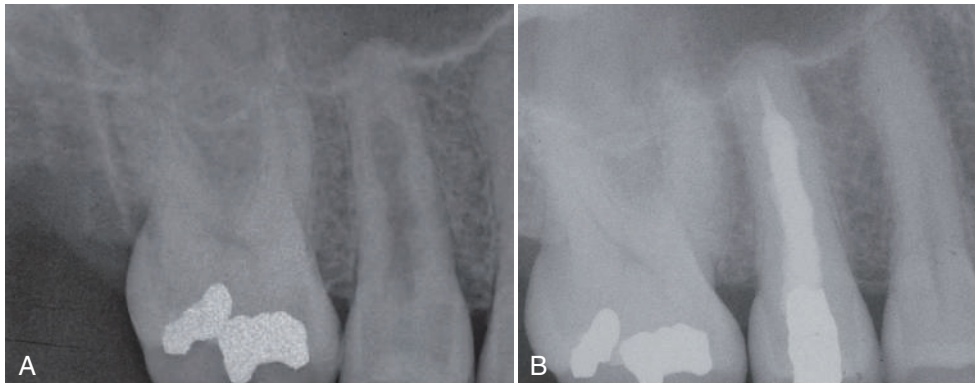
A, Internal root resorption in a maxillary premolar with a history of trauma 7 years before the diagnosis (patient's head slammed against side window during an automobile accident). B, Three-year follow-up radiograph after endodontic treatment.
